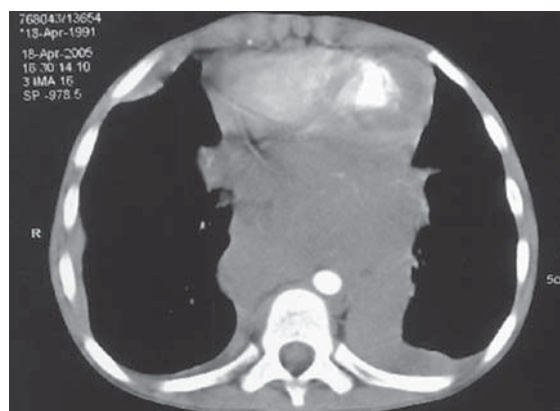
Chest CT shows a homogeneous mass in the posterior mediastinum.
